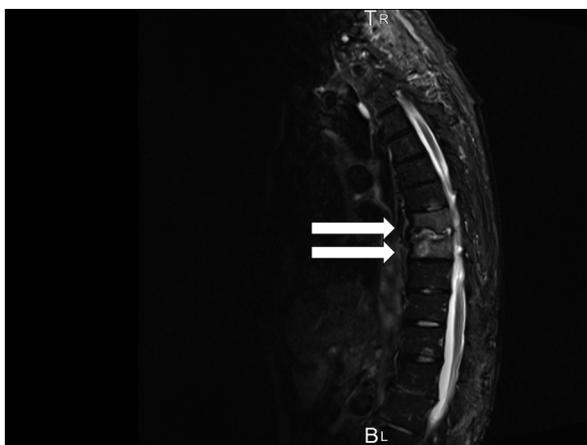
Magnetic resonance image showing abnormal intensity in 8th and 9th thoracic vertebrae (high signal intensity on a short-T1 inversion recovery-weighted image) (white arrow).
